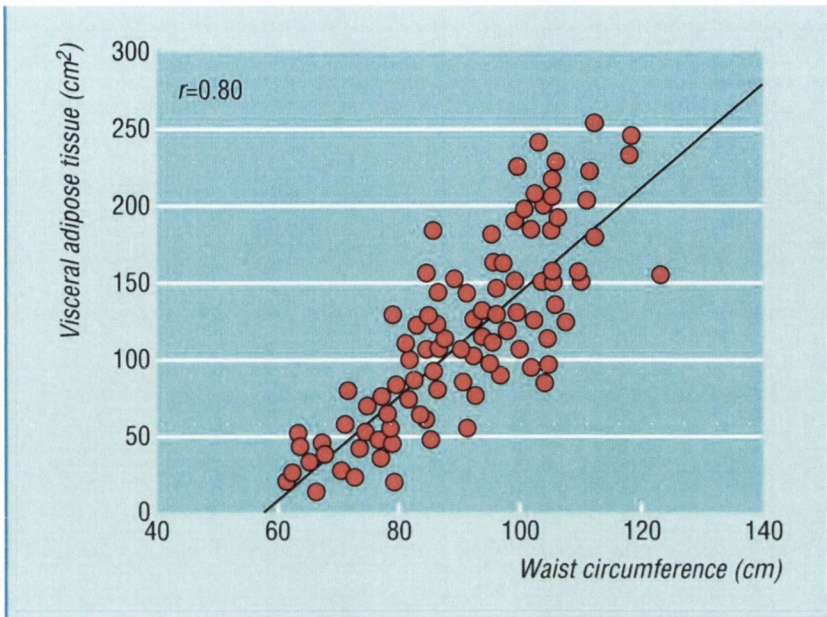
Waist circumference measurements are highly correlated with CT-measured visceral fat area. Figure from (Després et al., 2001); adapted from data in (Pouliot et al., 1994)
